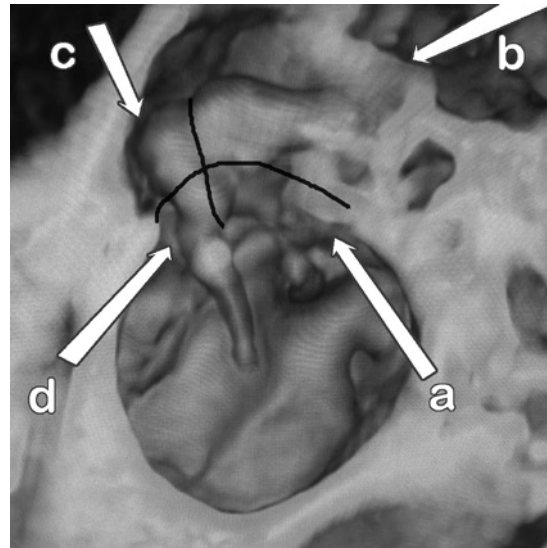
CT scan of the left ear (Parasagittal plane from multi-planar reconstruction with 3-D rendering). The black cross lies along the axis of the incudo-malleolar joint and along the base of the malleus head and incus body. This divides the medial epitympanum into four quadrants for planning surgical access to cholesteatoma: a. tympanic isthmus via ear canal; b. posterior epitympanum via mastoid; c. anterior epitympanum via ear canal or mastoid; d. supra-tubal recess via ear canal.
